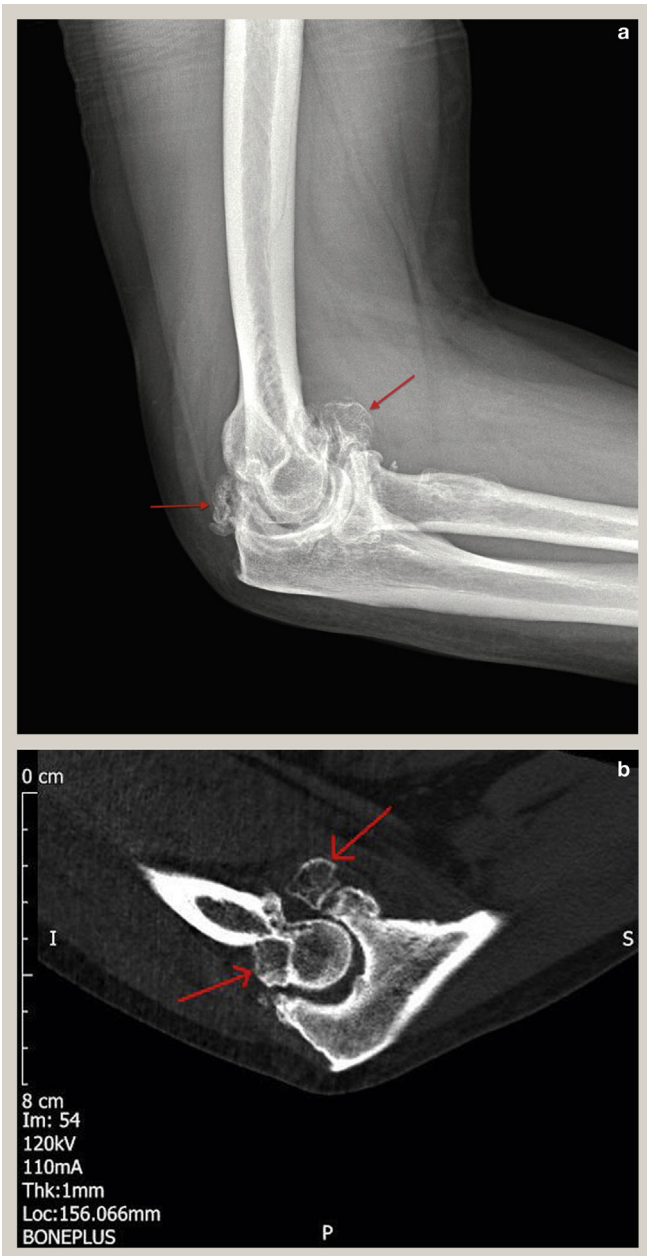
Plain lateral X-ray (a) and sagittal CT image (b) of osteoarthritic elbows. Arrows indicate osteophytes and loose bodies in the olecranon fossa which would limit extension, and in the coronoid fossa which would limit flexion.
